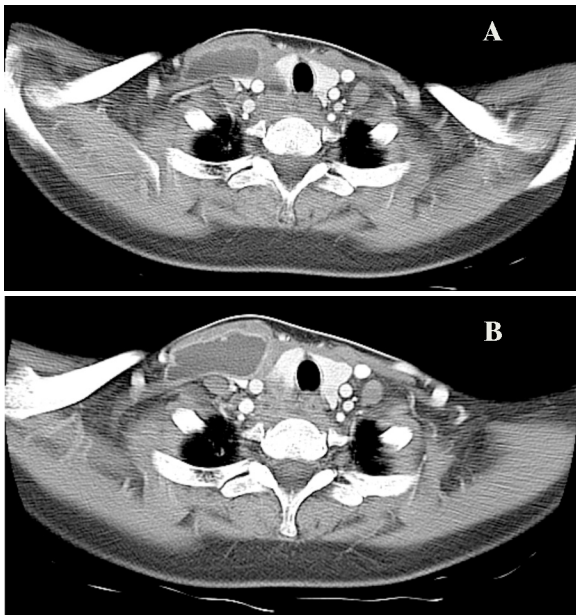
A the early showing the multi-loculated fluid collection at the right side of the thoracic inlet with major communicating pouches measuring 3.9x1.5 and 1.6 cm of possible thyroidal origin. B later scans taken on 10.8.2009 computed tomography showing an increase in the size of the abscess measuring 5.0x3.7x1.5 cm.
